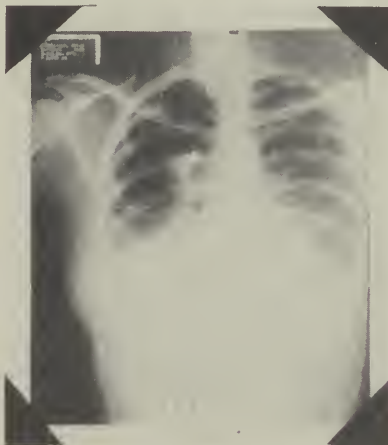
Preoperative roentgen film showing metallic foreign bodies in right upper lobe.
